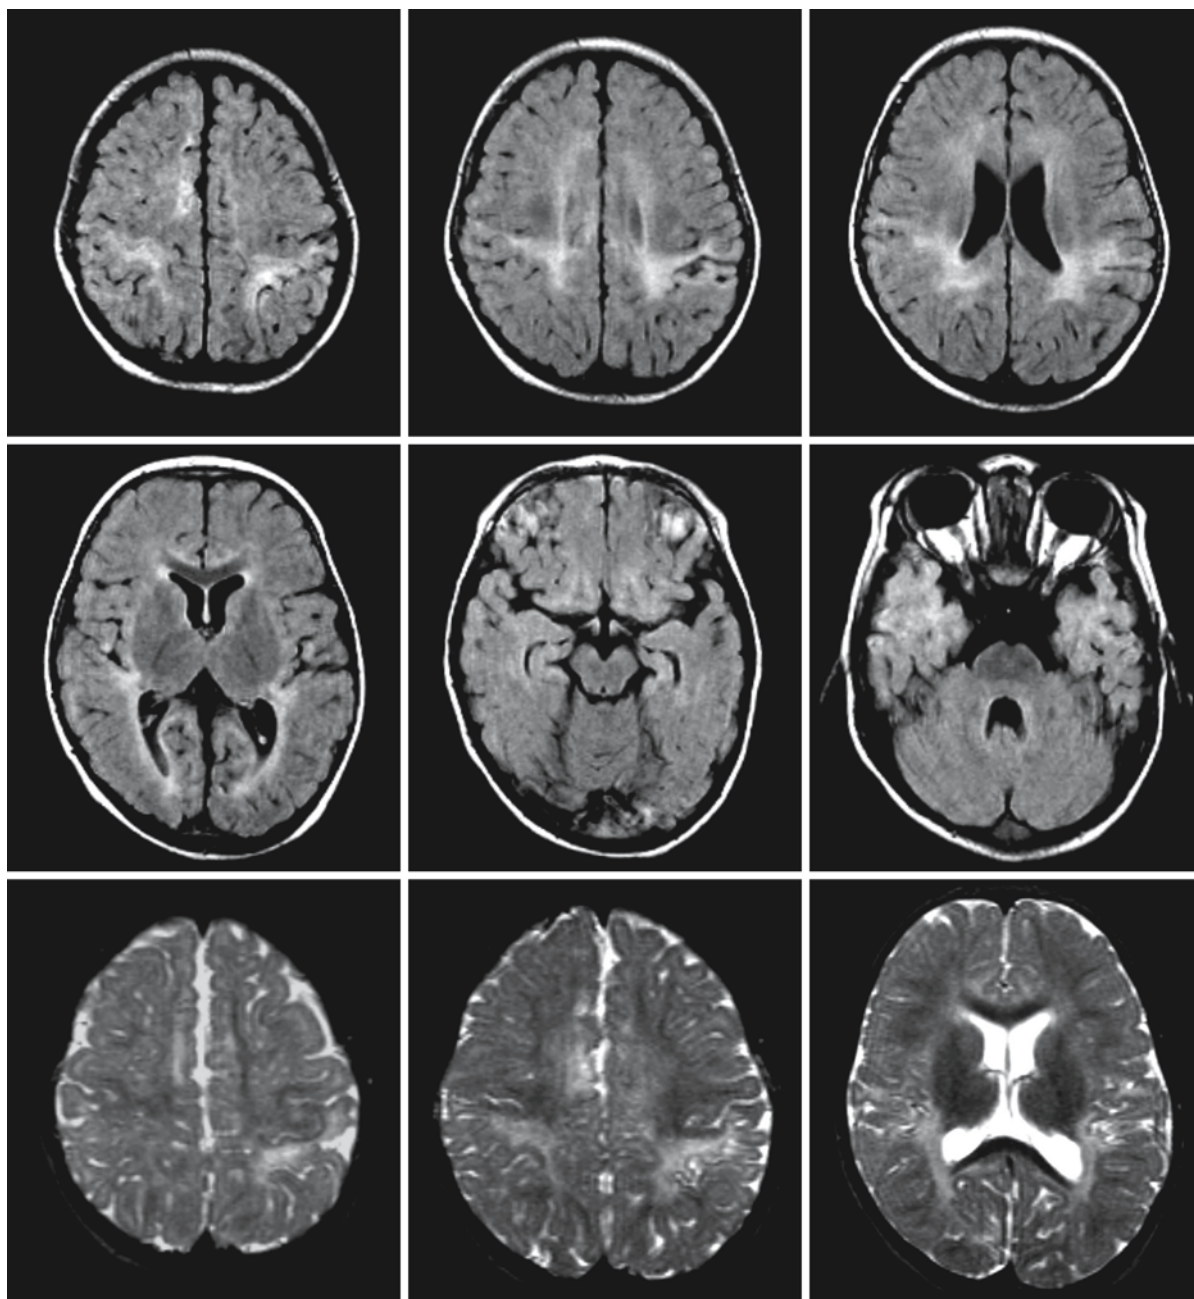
c* Follow-up MRI was obtained at the age of 14 months. The FLAIR (*first and second rows*) and T₂-weighted images (*third row*) show gliosis in the cortex and subcortical
